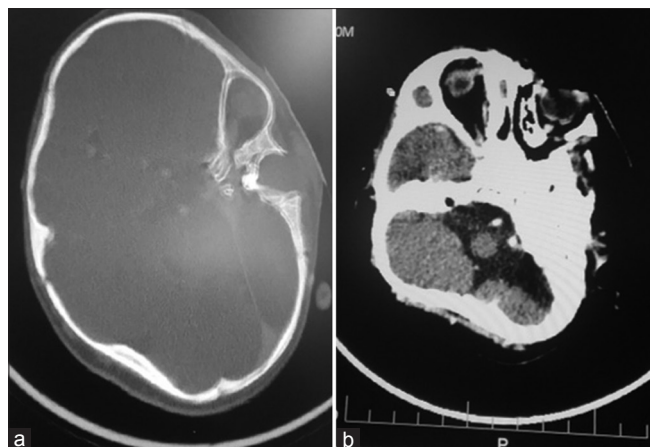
Axial computed tomography scan of the head showing two bony orbital cavities (vertical and horizontal double edged arrows) in the left temporal region (a) bone window (b) brain window
